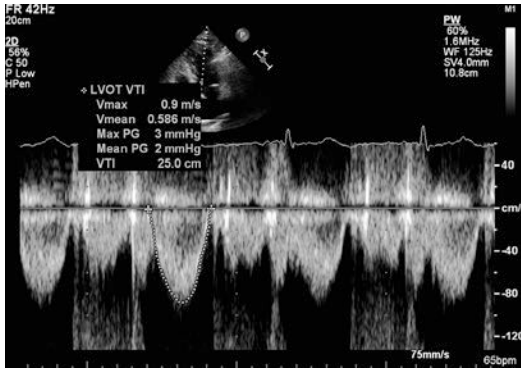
Pulsed wave Doppler recording from the apical 5-chamber view with sample volume placed just below the turbulent flow as it accelerates to become transaortic flow. Tracing of this spectral recording is shown with measurement of velocities obtained by tracing along the dense portion of the LVOT velocity envelope and excluding the low intensity signals on the outer edges of the spectrum
